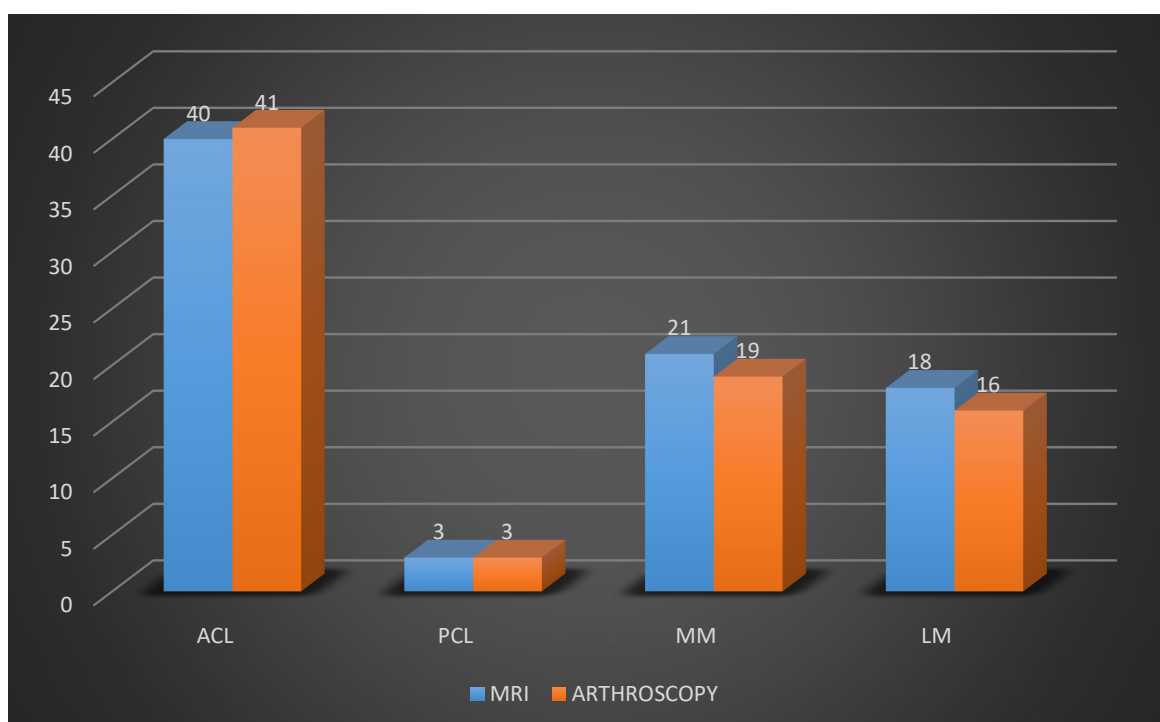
Total positive cases detected on MRI compared with true positive cases on Arthroscopy.
